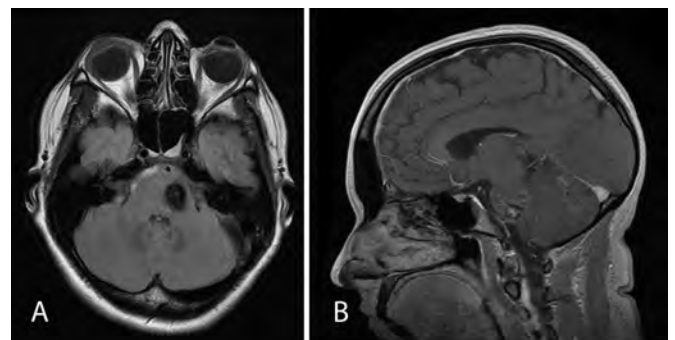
Three months postoperatively, an axial T2 fluid-attenuated inversion recovery image (A) shows a significantly reduced, homogenous, hypointense lesion that no longer abuts the surface of the brainstem. A sagittal T1-weighted image with contrast (B) shows no residual enhancement.
